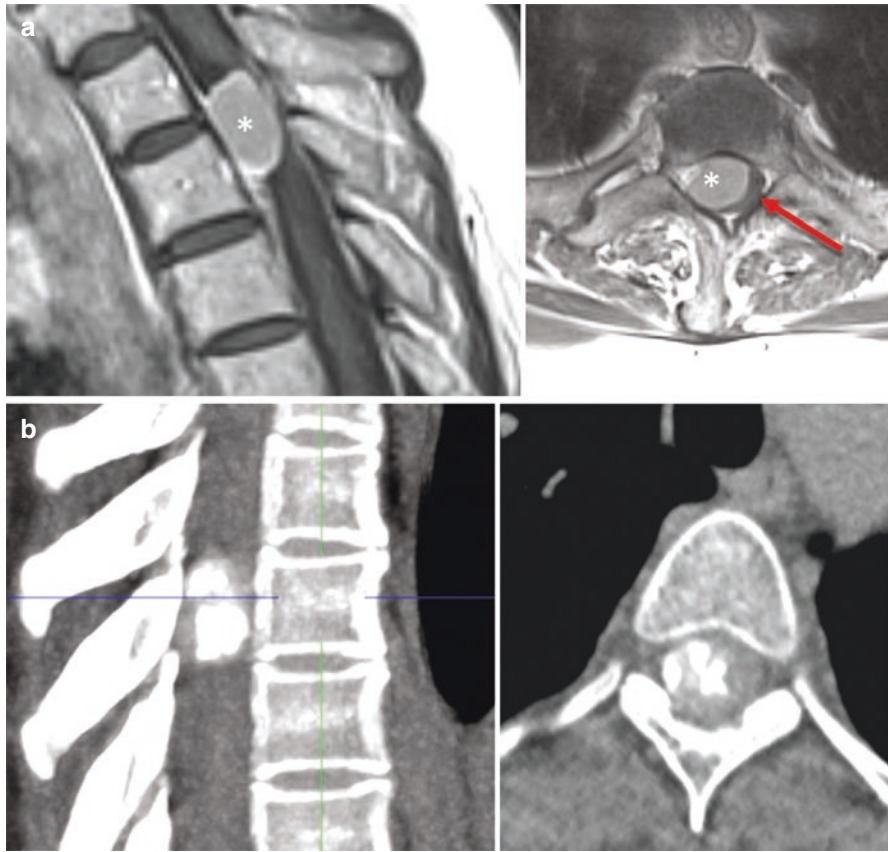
(a) T1WI MRI with contrast. Spinal meningioma (*) located anterolateral to the spinal cord (arrow). Tumor has a visible dural tail. (b) CT thoracic spine demonstrated a highly calcified intradural tumor. This can be particularly challenging if located anterior to the spinal cord
